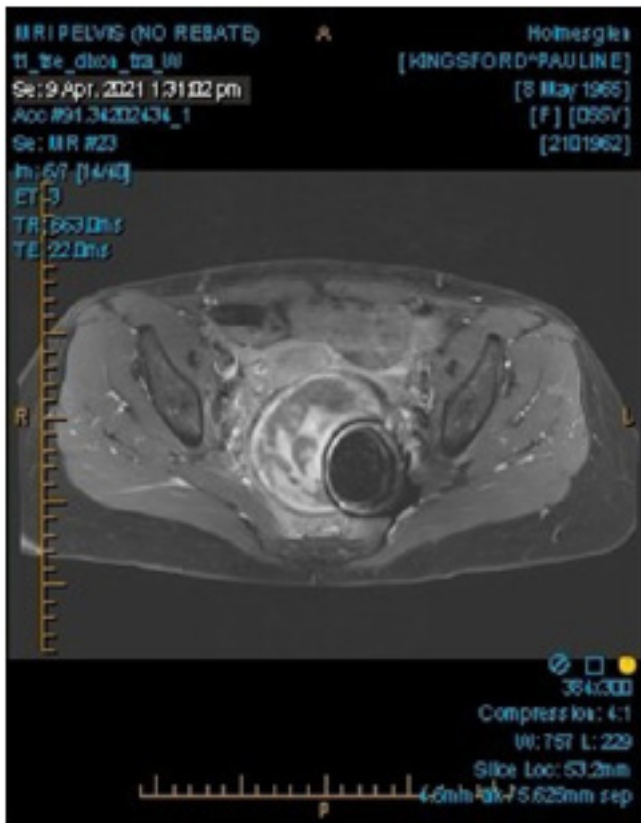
Cross sectional MRI view of rectal haematoma day 9.
